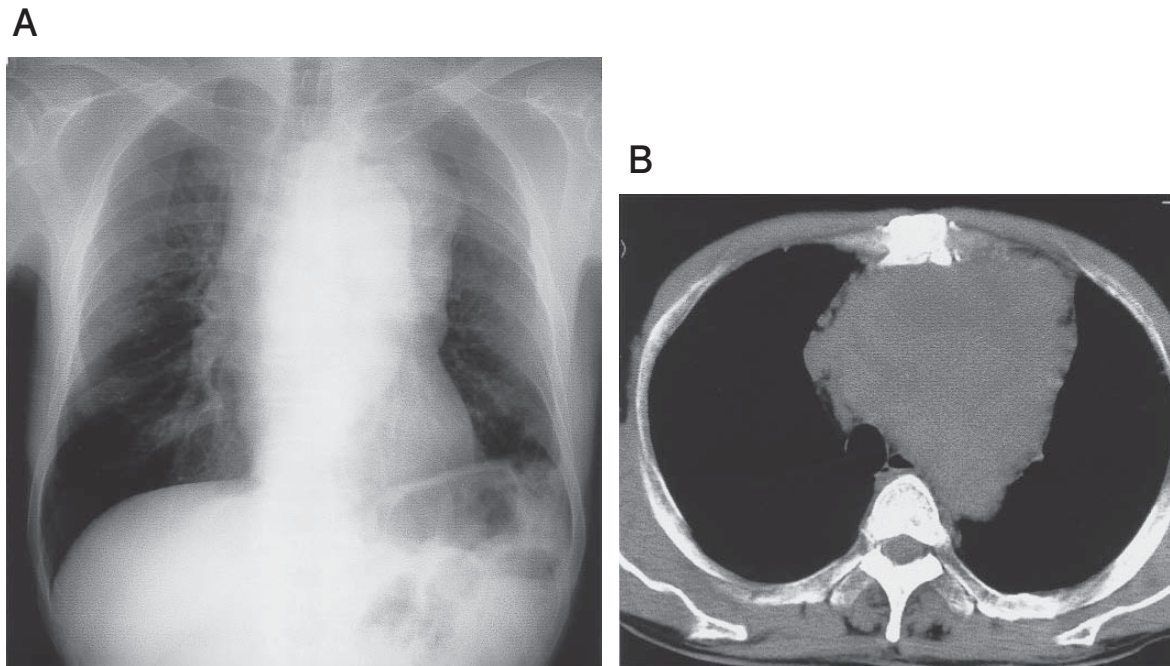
A chest plain radiography and computed tomography (CT) of the chest revealed a 10 × 8 cm anterior mediastinal mass.
